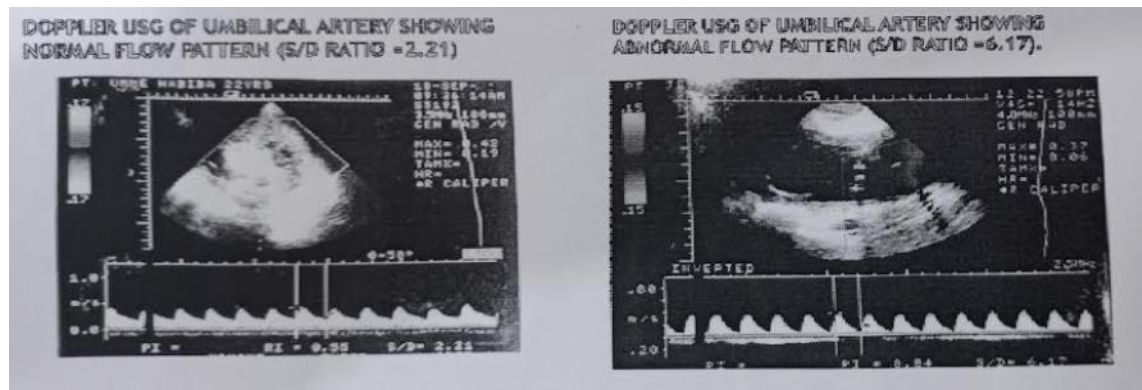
Doppler UsG Of Umbilical Artery Showing Normal Flow Patiern (5/D Ratio -2.21)/Doppler UsG Of Umbilical Artery Showing Abnormal Flow Patiern (5/D Ratio -6.17).
